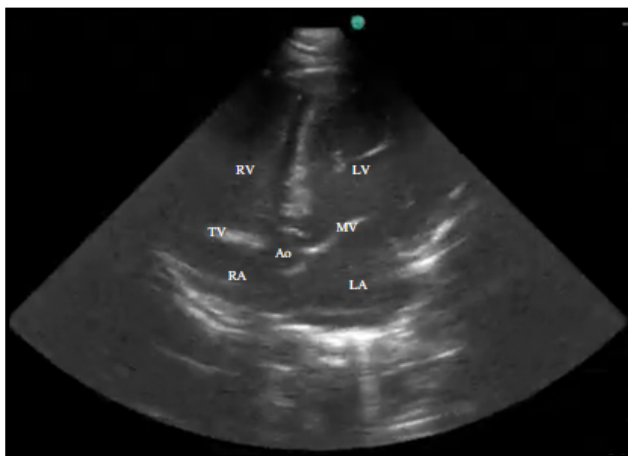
Echocardiographic assessment in the 5-chamber apical view of an adult female giant anteater (*Myrmecophaga tridactyla*) rescued in the state of Paraná, Brazil. [RA= Right atrium; RV= right ventricle; LA= left atrium; LV= Left ventricle; Ao= aorta; MV= Mitral valve; TV= Tricuspid valve].
